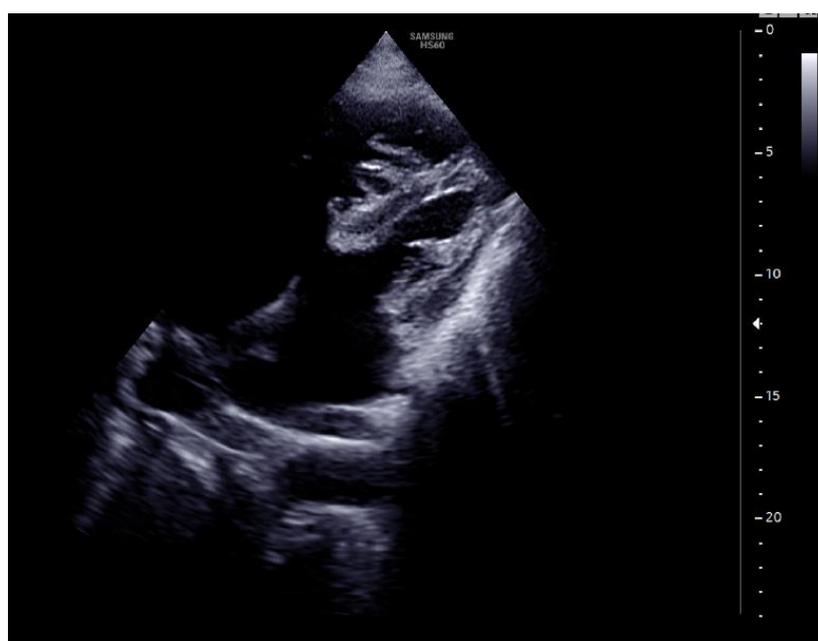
Echocardiography view showing the mitral valve cleft
